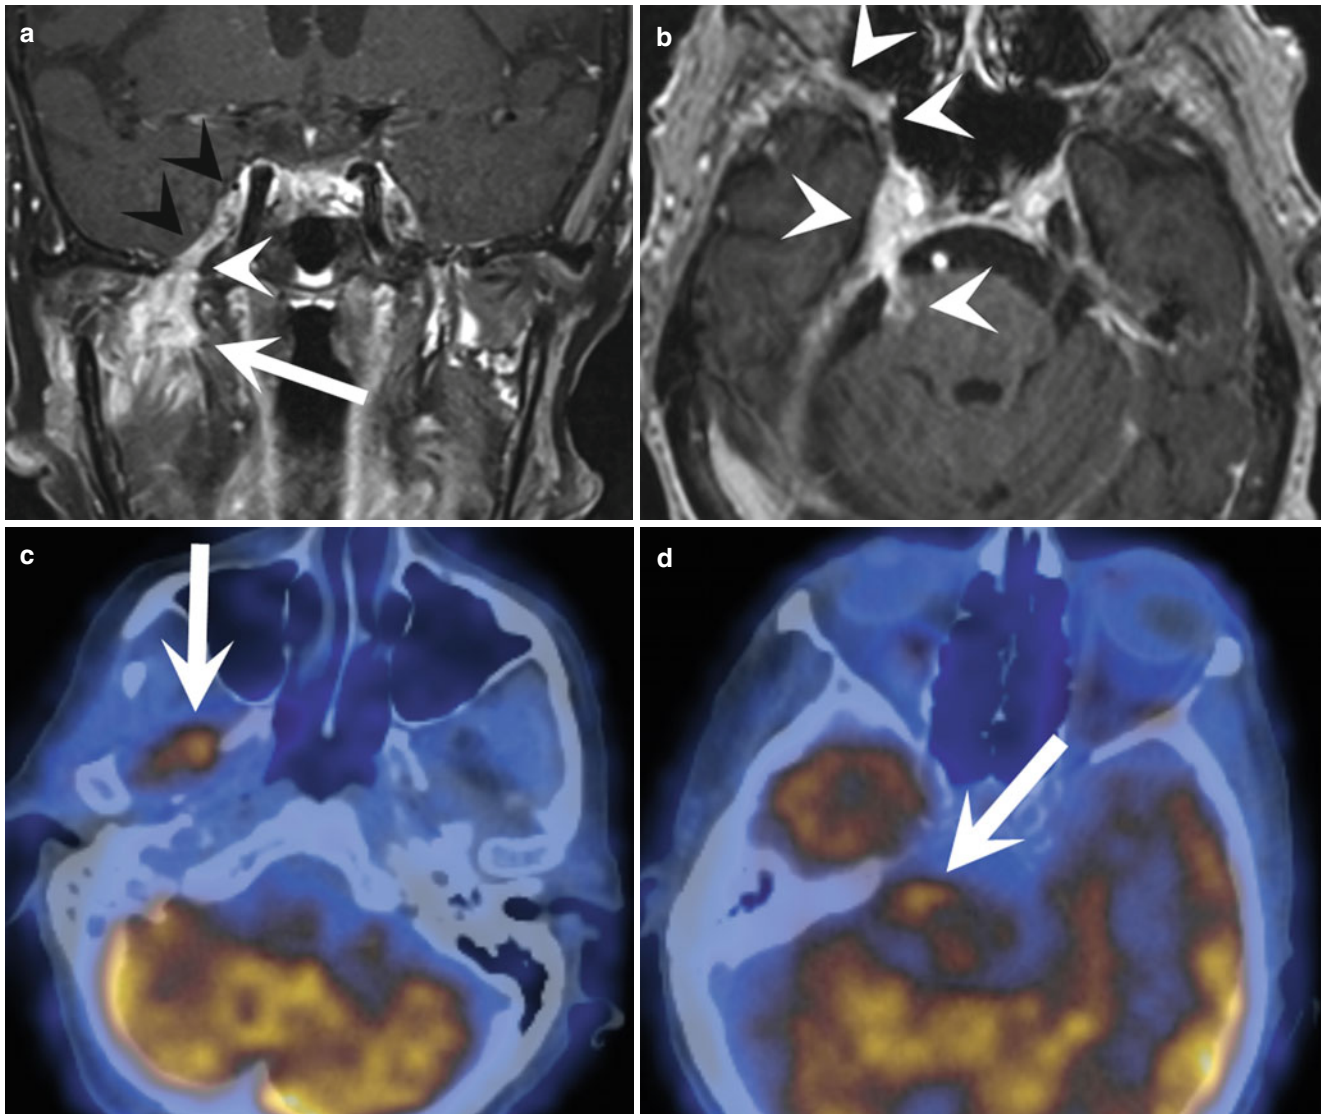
Patient with right-sided facial nerve palsy and pain in the cheek. Contrast-enhanced T1-weighted fat-suppressed coronal MR image (a) shows a tumor in the deep lobe of the right parotid gland (arrow). The mandibular nerve is thickened and enhances (black arrow heads) along its course from the cavernous sinus via the foramen ovale (white arrow head) to the masticator space. Axial contrast-enhanced T1-weighted coronal MR image (b) confirms extensive perineural
